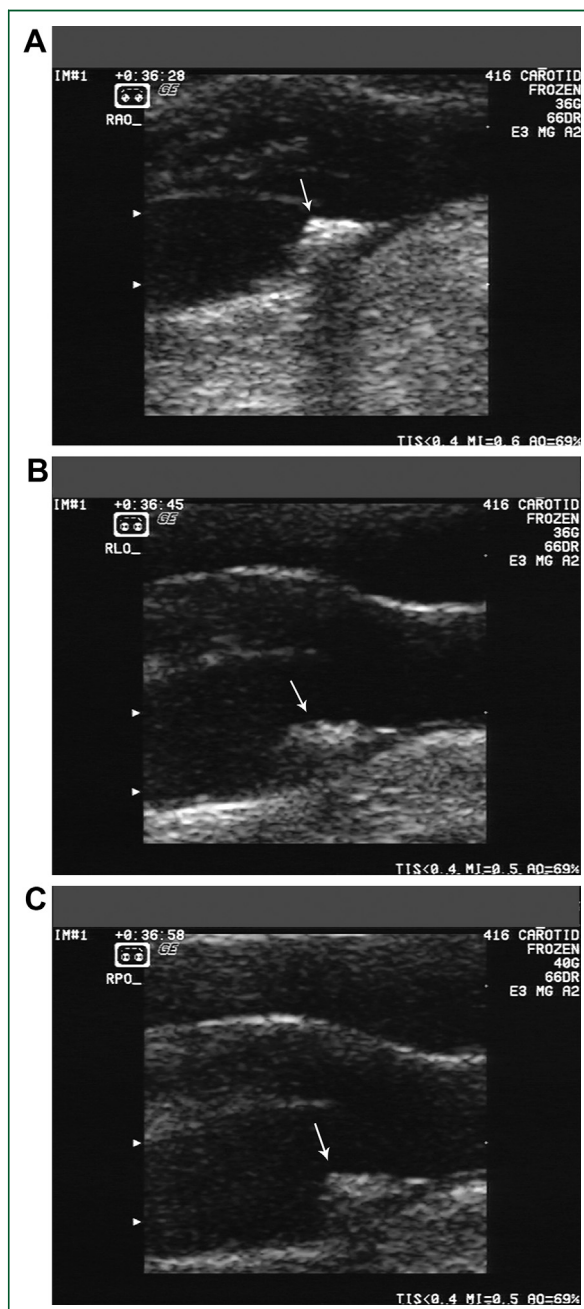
Images demonstrating how the sonographer attempted to better delineate a plaque by minimally changing the acquisition positions. (A, B, C) A plaque (arrow) and the flow divider are seen on all 3 projections.
